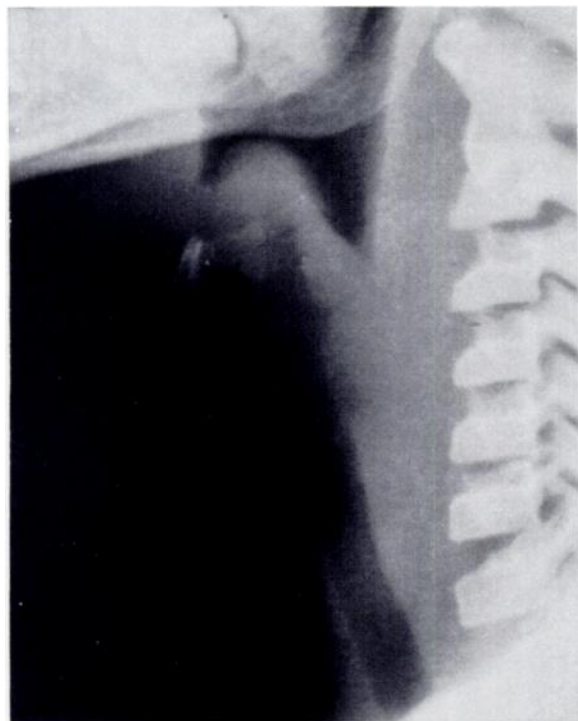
Case 5. Lateral airway radiograph showing markedly swollen epiglottis with encroachment on valleculae. Subglottic edema is not as apparent in this projection as in fig. 3E.
